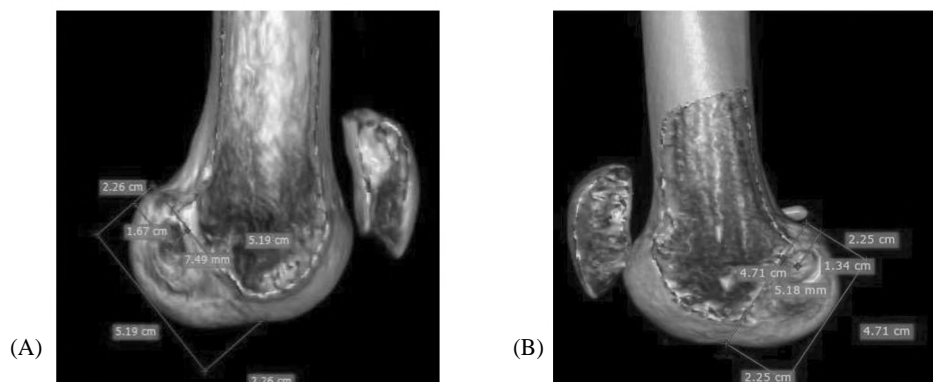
3D CT after digital subtraction of the medial femoral condyle, exposing the medial wall of the lateral femoral condyle, then applying the template of quadrant method.
